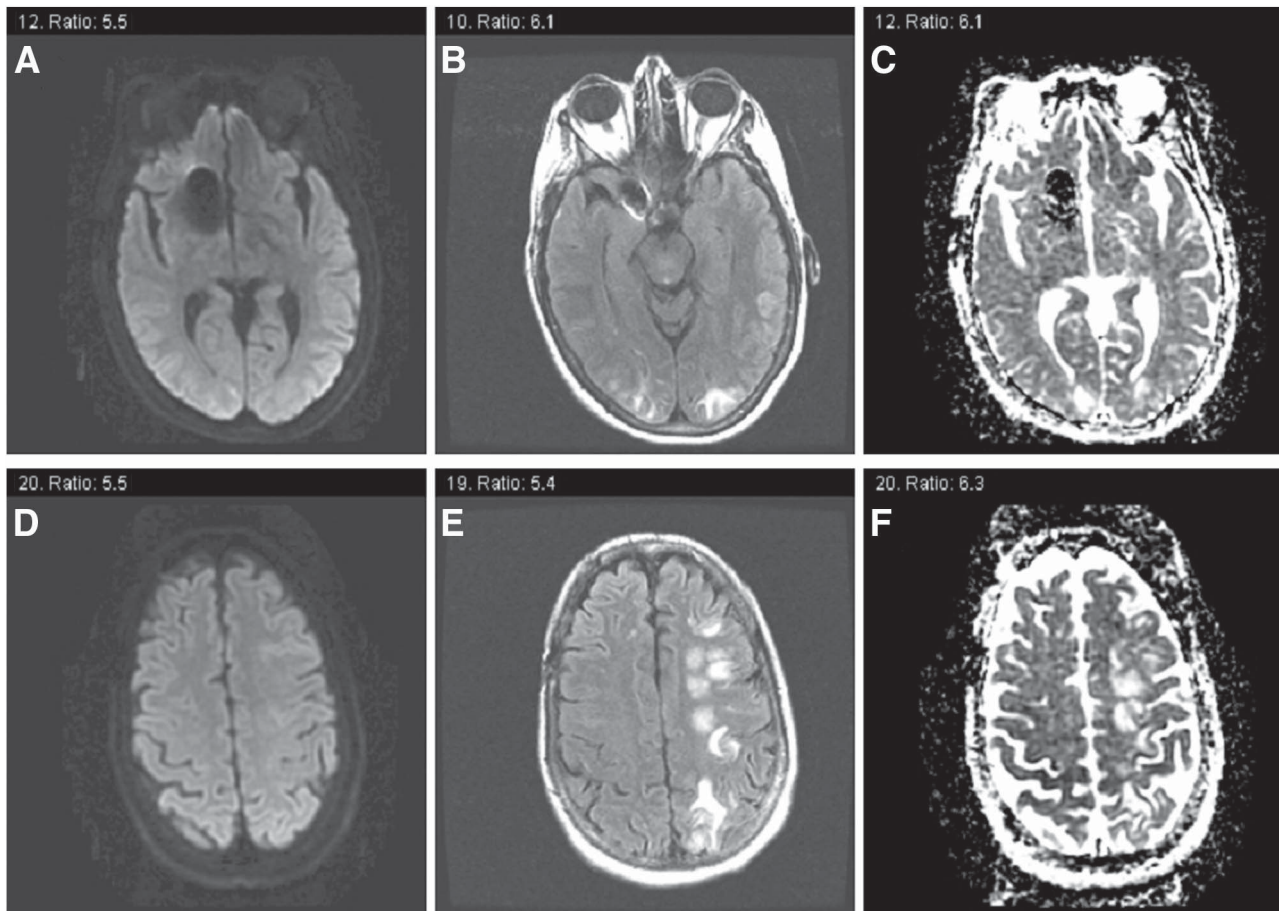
Non-contrast brain magnetic resonance imaging, demonstrating changes consistent with asymmetric reversible posterior leukoencephalopathy. (A) A diffusion-weighted image (DWI), essentially normal (with the exception of artifact created by her aneurysm clip). (B) A fluid-attenuated inversion recovery (FLAIR) image with changes affecting the subcortical white matter of the classic locations in the parieto-occipital regions. (C) The apparent diffusion coefficient (ADC) map showing increased signal consistent with increased diffusion of water (and not restricted diffusion, which would be characteristic of ischemia/infarction). (D) DWI, (E) FLAIR, and (F) ADC show similar changes affecting the anterior hemisphere white matter, but only on the left.
